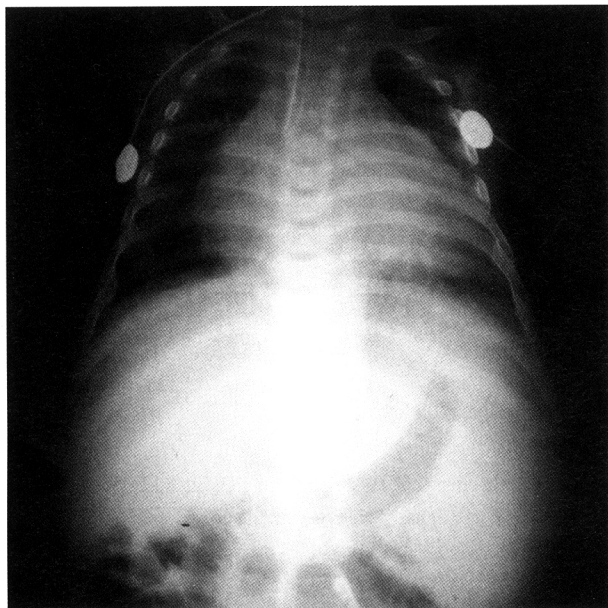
Chest radiograph shows cardiomegaly.
